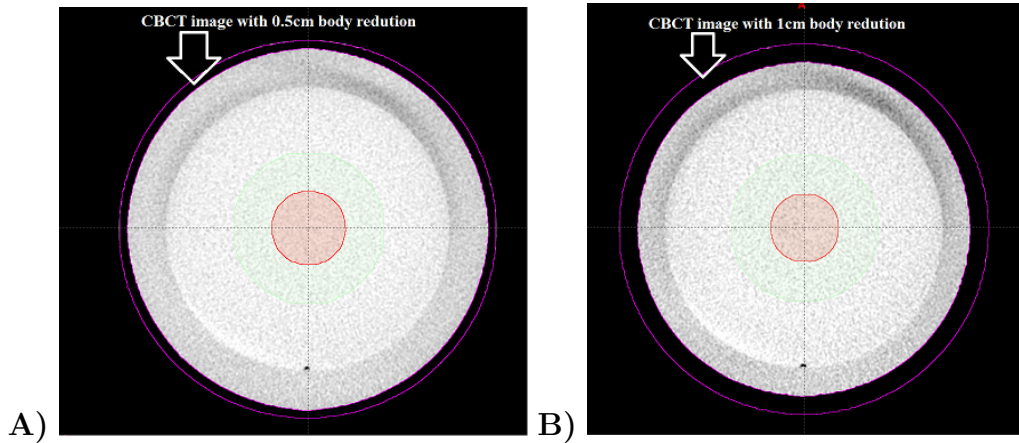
A) Axial CBCT images of the Catphan with 0.5 cm body reduction and B) with 1 cm body reduction
